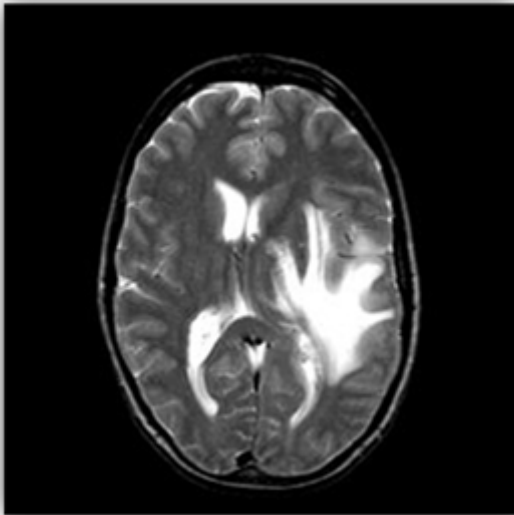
MRI brain image [5]
